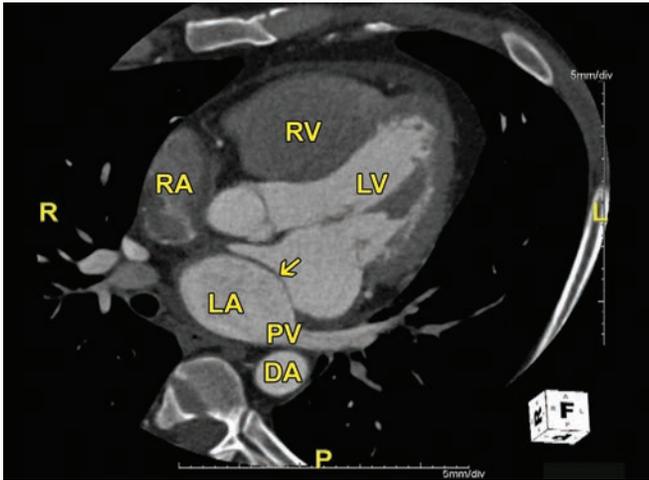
Cardiac computed tomography. Arrow points to a linear structure within the left atrium.
